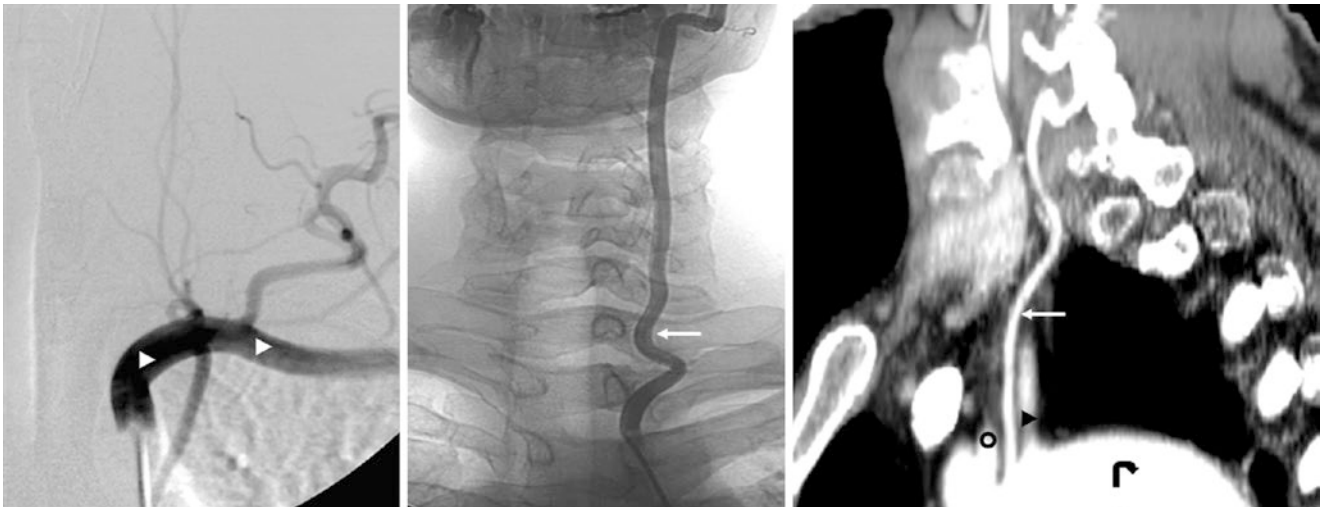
In a 21-year-old, a catheter DSA injection of the LSCA origin in an AP view (*left*) did not depict the LVA origin, but its “arch origin” was found by selective catheterization (*middle*), and on an LAO MPR from a CTA (*right*). *Aortic Arch* (curved arrows); *IA* Innominate
